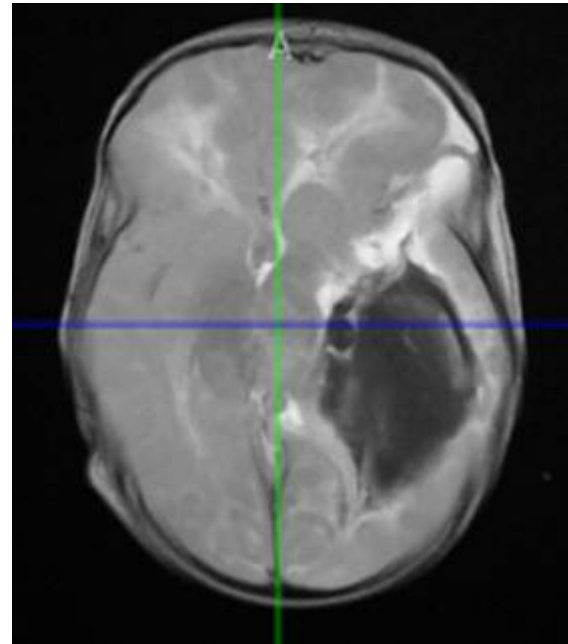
Brain MRI showed large hemorrhage in the left cerebral hemisphere.
